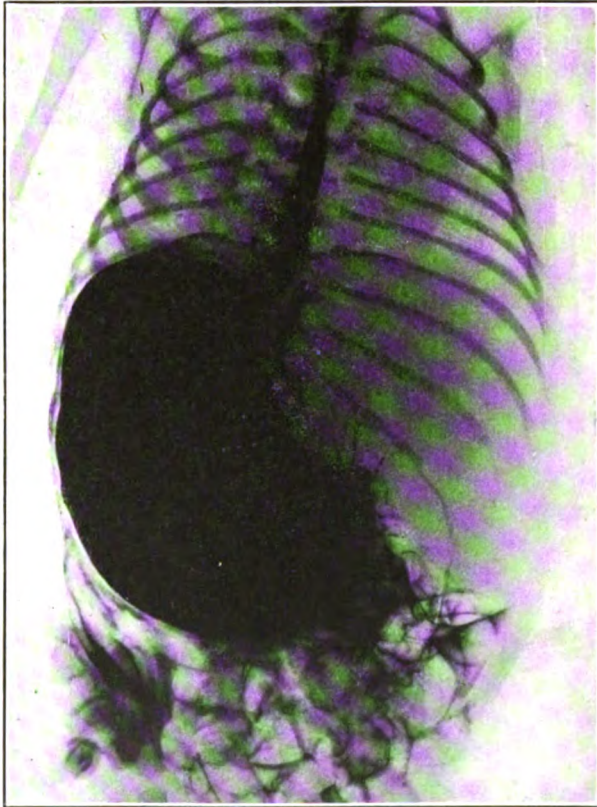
Roentgenogram showing position of stomach in a still-born, full-term infant.
